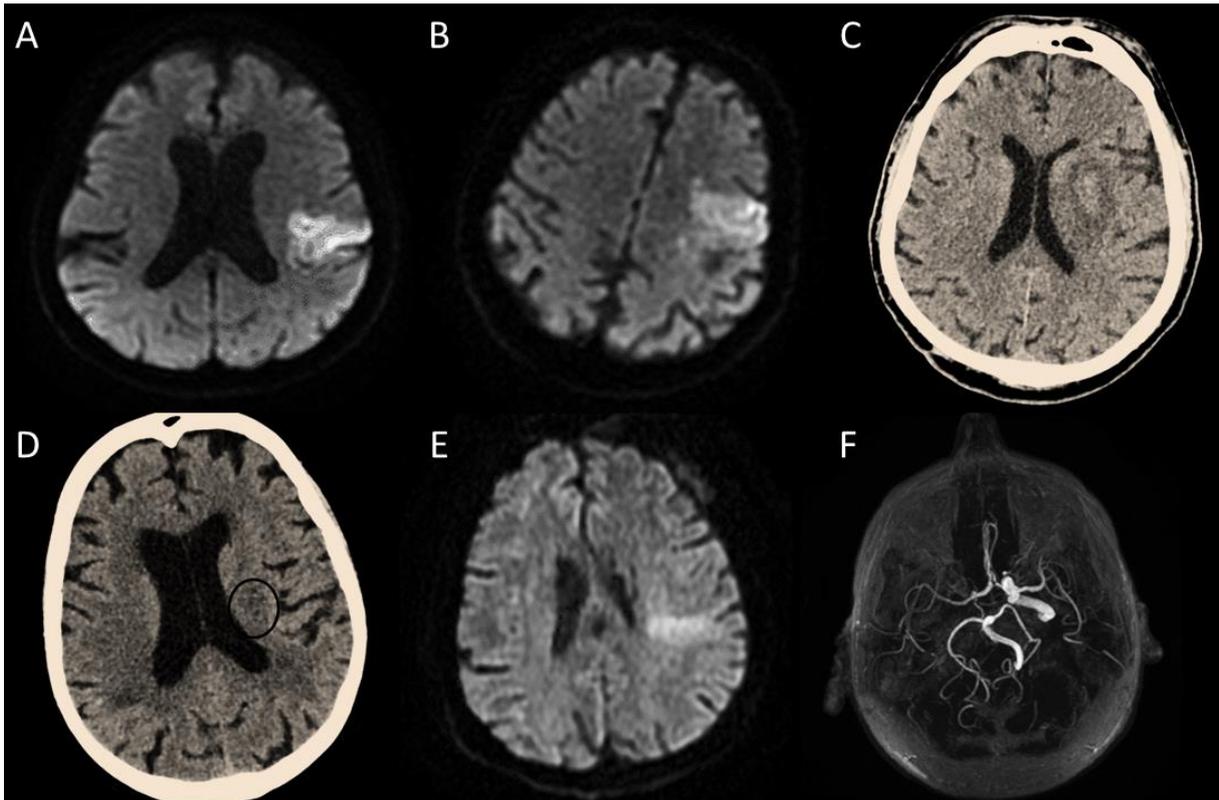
CT and MRI scans of patients approximately 24 hours after reperfusion treatment. A) DWI scan of Patient 1, showing left MCA territory cortical hyperintensity. B) DWI scan of Patient 2 shows a similar, embolic-appearing acute brain infarct. C) Non-contrast CT (NCCT) scan of Patient 3 after thrombectomy. The infarct involves the left basal ganglia, internal capsule and corona radiata. D) NCCT of Patient 4 shows slight hypodensity in the left corona radiata. E) DWI scan of Patient 5 shows a left MCA territory infarct. F) Patient 5's MRA-TOF reconstruction demonstrates enlarged left ICA and MCA.
